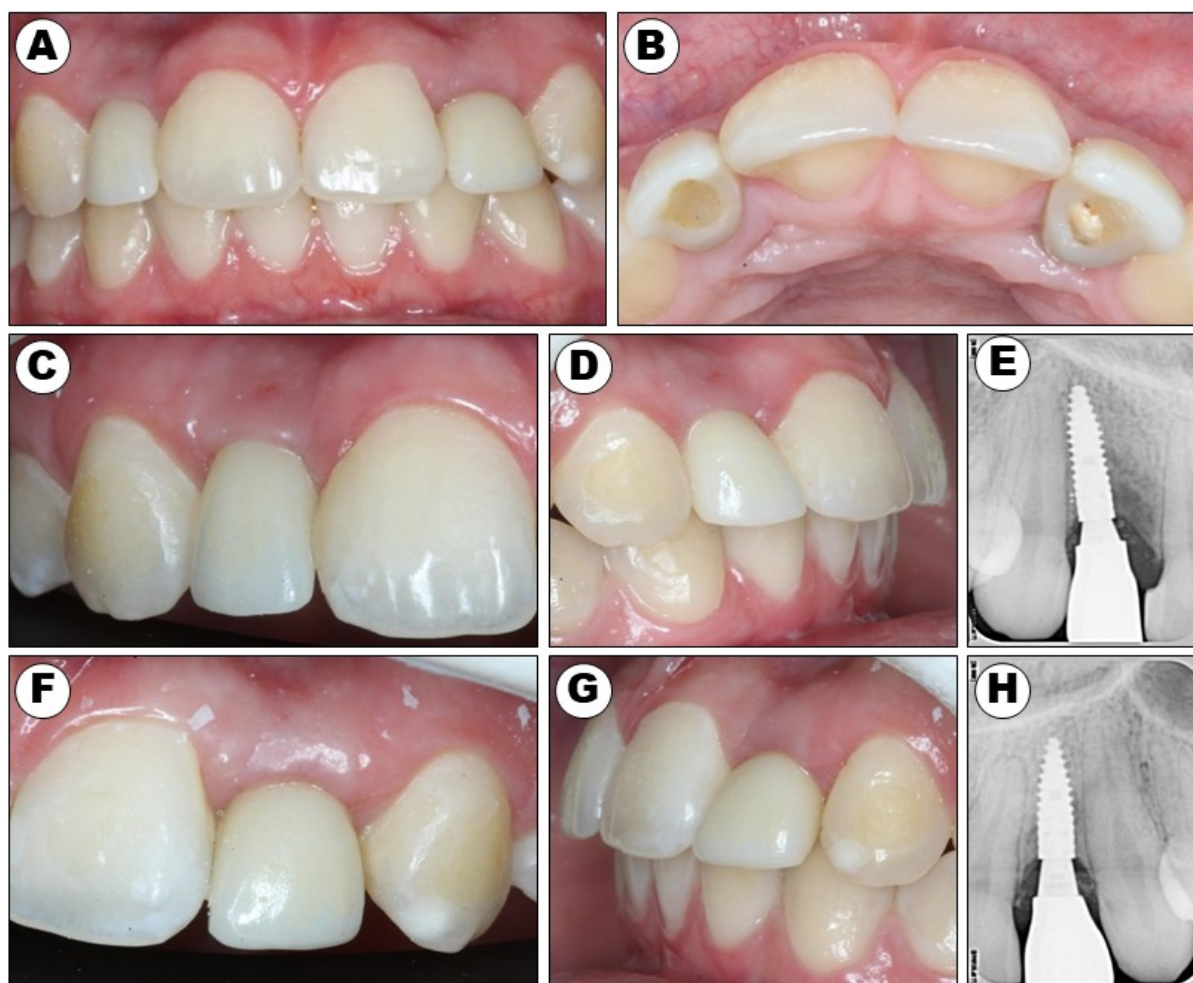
A: Clinical appearance two months after zirconia crown placement - Front view B: Occlusal view C: Detailed front view of region 12 D: Lateral view of region 12 E: Periapical radiographs after installation of zirconia crowns on Variobase® of region 12 F: Detailed front view of region 22 G: Lateral view of region 22 H: Periapical radiographs after installation of zirconia crowns on Variobase® of region 22
